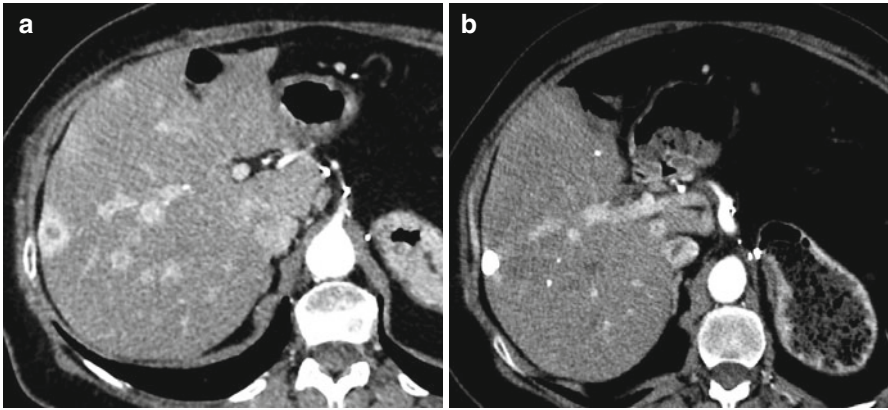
A 76-year-old man with pancreatic neuroendocrine tumor and multiple liver metastases. (a) Axial CT scan shows hypervascular lesions at the arterial phase. (b) Axial CT scan after chemoembolization using streptozotocin shows a major lipiodol uptake of lesions with no residual hyperarterial tumor suggesting complete response
